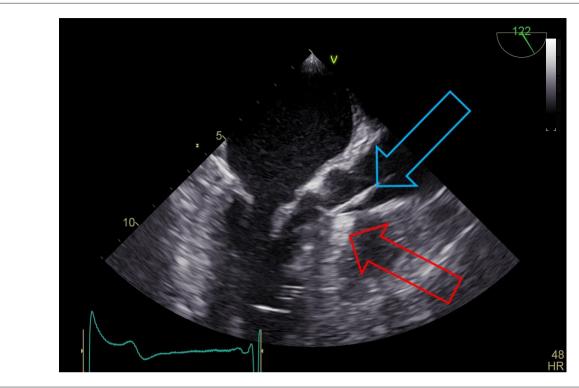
Perioperative transesophageal echocardiography, which shows the refringent interventricular septum (red arrow) and the radiofrequency (RF) therapeutic catheter, which, after surpassing the aortic valve, is impacted on the septum (blue arrow). This region is defined by the echocardiography professional as the one with the highest gradient. At this point, RF is applied and, if the gradient is reduced in at least 25%, new applications are repeated around the first application, thus extending the lesion area.
